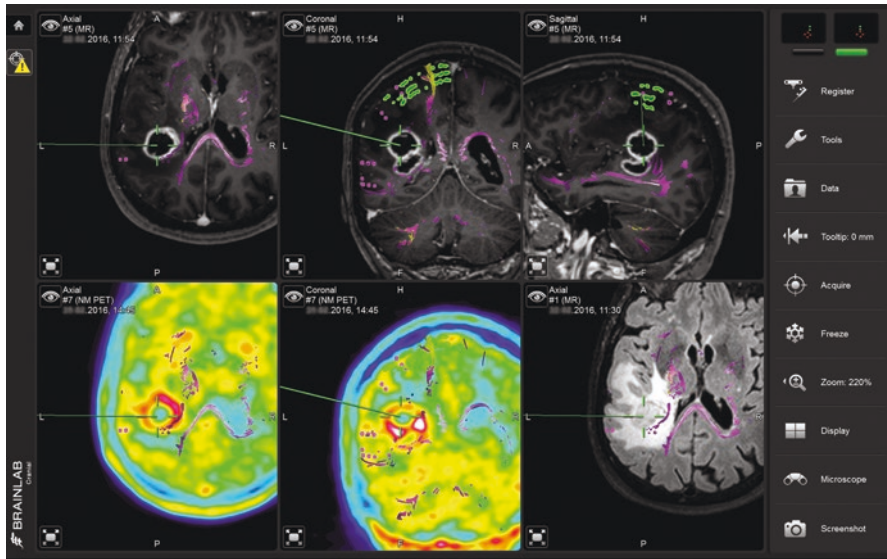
Intraoperative use of the surgical neuronavigation system. After implementation of datasets containing nTMS spots and nTMS-based tractography, further MRI or PET sequences can be added to the image stack (here: Brainlab Curve). The motor-positive nTMS spots are visualized in *green* and the CST is displayed in *yellow*. Language-positive nTMS spots and subcortical language-related pathways are depicted in *pink*
